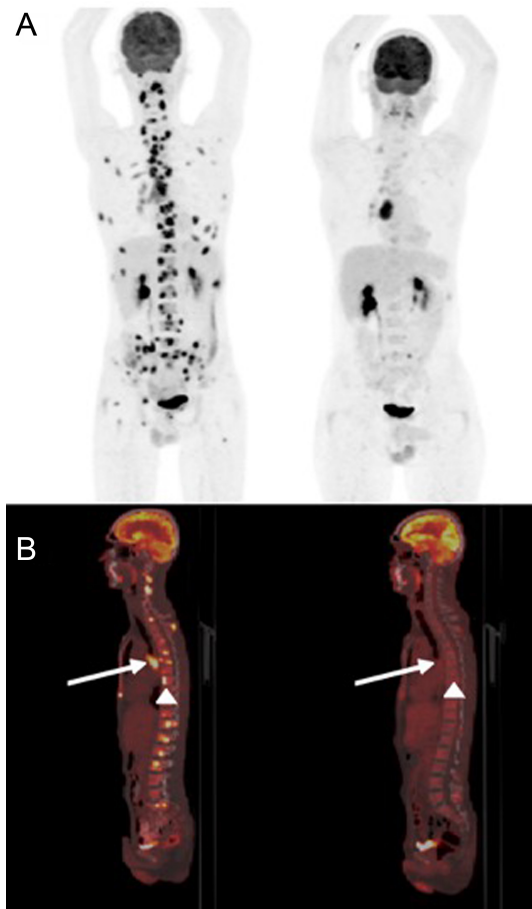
18-F FDG PET/CT scan showing EP TB in a 32-year-old male patient. Initial and after anti-TB treatment control PET studies are shown (left-to-right columns). Whole-body maximum intensity projection images are shown (A). Trans-sagittal-fused images showing FDG-avid subcarinal lymph node (B; arrows) and bone lesions (B; arrowheads) regression after anti-TB treatment. CT, computed tomography; EP, extrapulmonary; 18-F FDG, fluoro-2-d eoxy-D-glucose; FDG, fluorodeoxyglucose; PET, positron emission tomography; TB, tuberculosis.
